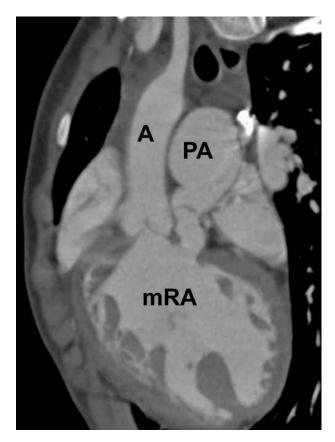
CT coronal image in 6 year old girl with double outlet right ventricle, has aortic root (A) and main pulmonary trunk (PA) arising in a parallel plane from morphological right ventricle (mRV), which has thick and coarse trabeculae
